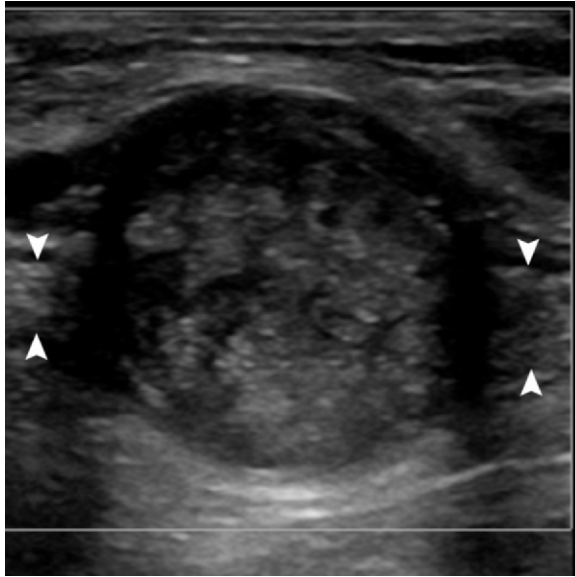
Median nerve schwannoma. Longitudinal US image shows a circumscribed, fusiform mass with mixed echogenicity along the course of the median nerve. The proximal and distal portions of the median nerve are seen (arrowheads). Color Doppler US showed no appreciable vascularity.
